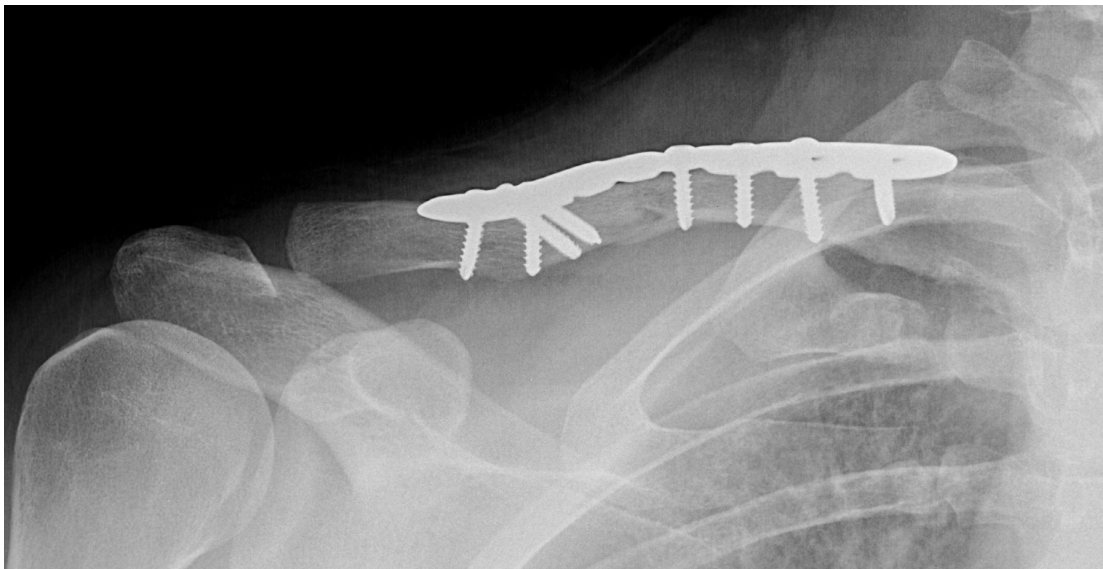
B : LCP Superior Clavicle Plate (postoperative x-ray)
